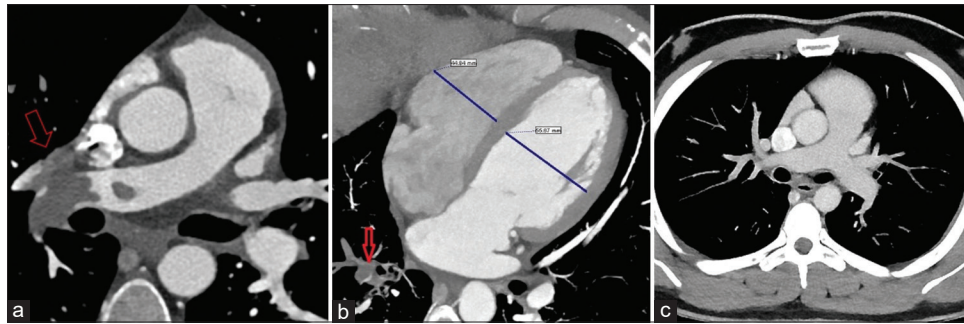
(a) CT shows pulmonary embolism in the right pulmonary artery (red arrows indicate the pulmonary embolus); (b) Right chamber sized were normal in the CCTA (Right ventricle: 45 mm, Left ventricle: 56 mm; RV/LV < 0,9); (c) The pulmonary computed tomography angiography was normal at the 3-month follow-up
